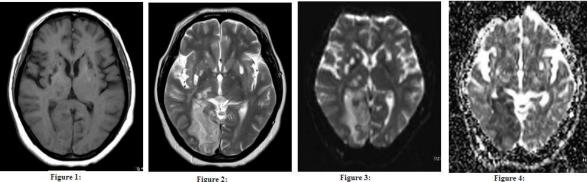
AXIAL T 1WI; Figure 2: AXIAL T2 WI; Figure 3: AXAL DWI; Figure 4: AXIAL ADC MAP
